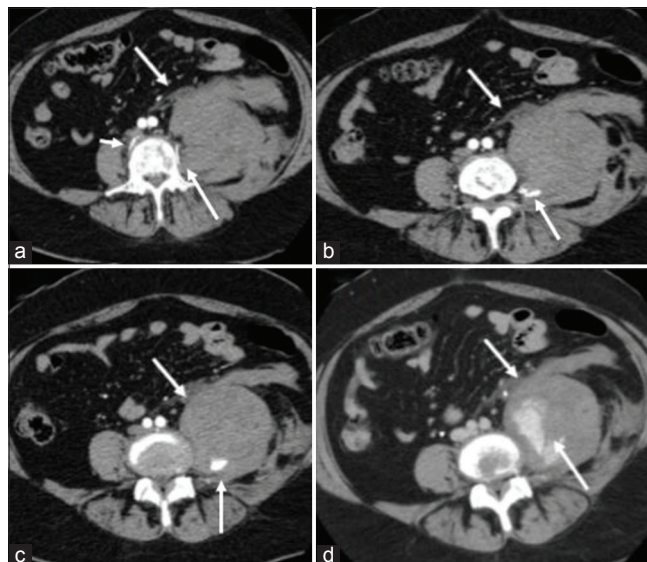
(a-d) Sequential images of computed tomography angiography were suggestive of breach in the left lumbar segmental vessel at L4 level (arrow).
